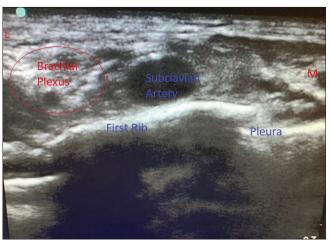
Ultrasound image 18 h after block
